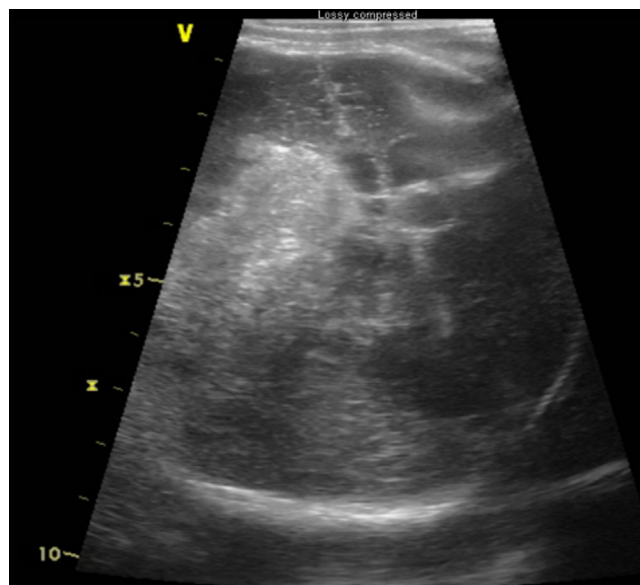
Twin #2 of the first set of twins. Brain ultrasound demonstrating intraventricular hemorrhage grade 4 (right) and grade 3 (left) and deviation of the septum as a sign for the increased intracranial pressure.
